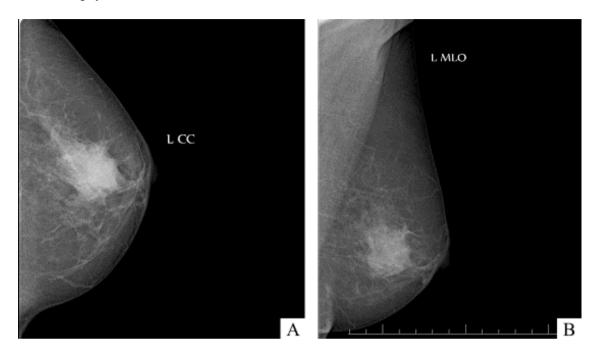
X-ray mammography images, craniocaudal (Fig A) and Mediolateral (Fig B) images demonstrating an irregular high density lesion with spiculated margins in lower outer quadrant of left breast.
